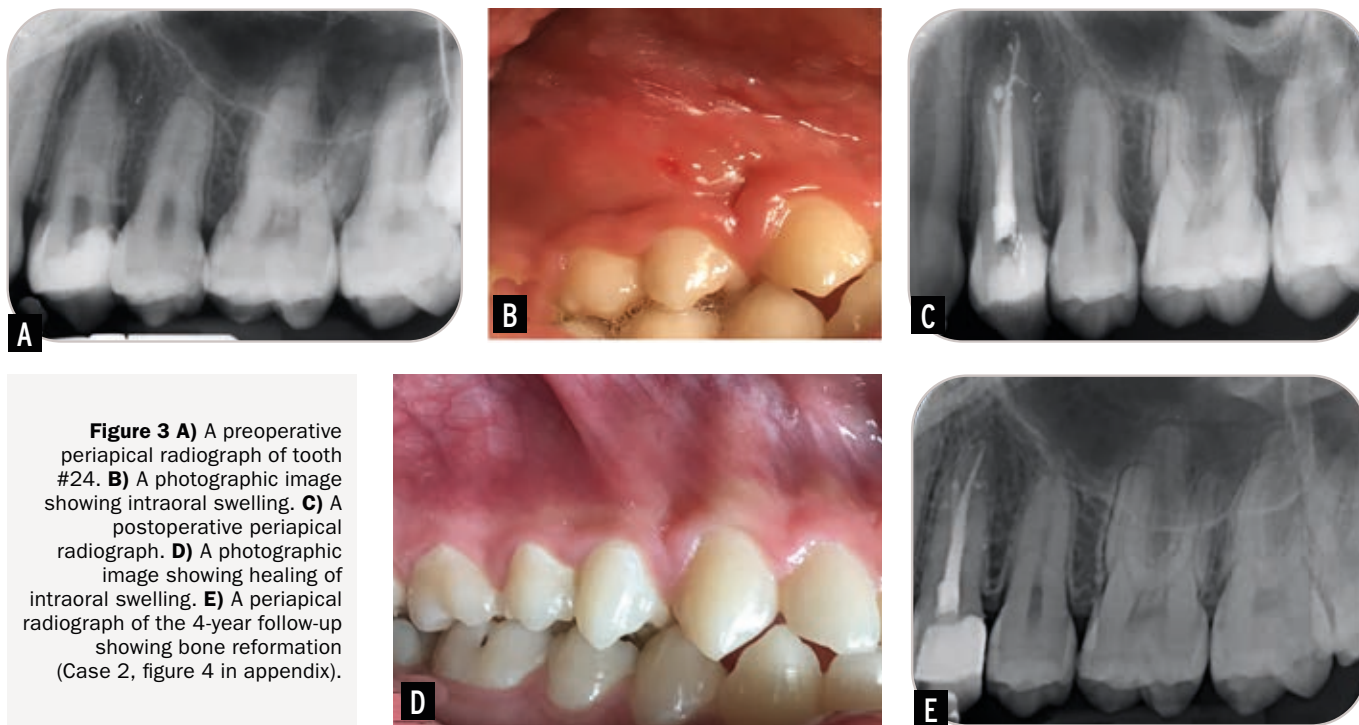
A) A preoperative periapical radiograph of tooth #24. B) A photographic image showing intraoral swelling. C) A postoperative periapical radiograph. D) A photographic image showing healing of intraoral swelling. E) A periapical radiograph of the 4-year follow-up showing bone reformation (Case 2, figure 4 in appendix).
